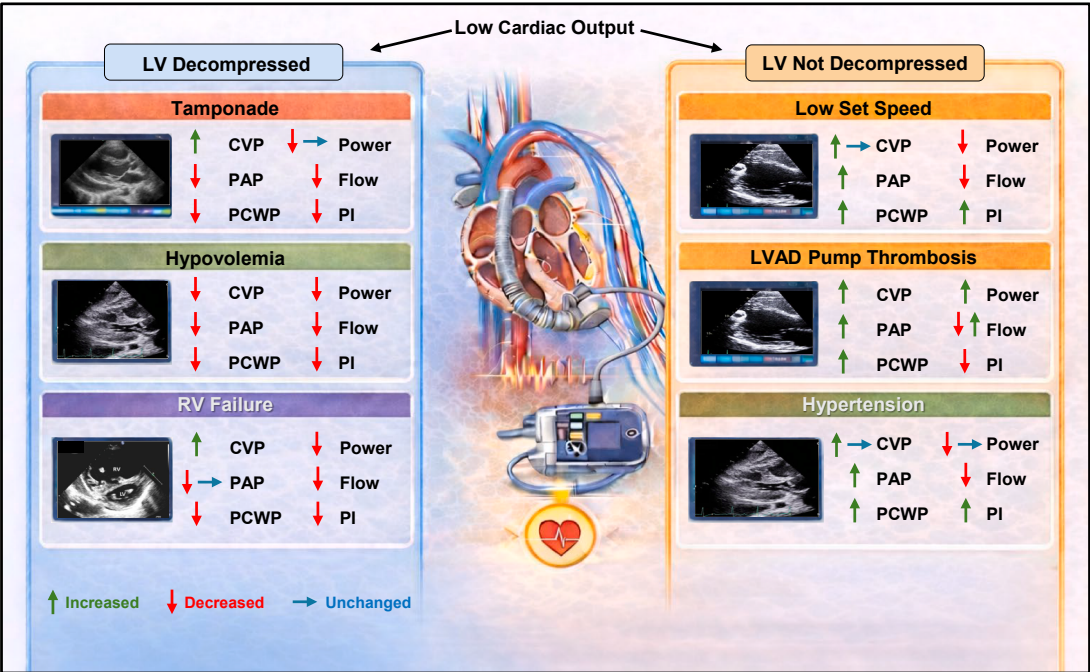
Multimodality assessment of low cardiac output after LVAD implantation. Integrated echocardiographic, invasive hemodynamic, and LVAD console data used to differentiate common causes of low cardiac output in continuous-flow LVAD patients. LV cavity size (decompressed vs not decompressed) is determined by echocardiography; CVP, PAP, and PCWP are obtained from invasive hemodynamic monitoring; and LVAD power, flow, and PI are derived from the LVAD console. Etiologies are stratified as LV decompressed (tamponade, hypovolemia, RV failure) or LV not decompressed (low pump speed, pump thrombosis, hypertension). Arrows denote direction of change relative to baseline (green = increased, red = decreased, blue = unchanged). CVP, central venous pressure; LVAD, left ventricular assist device; PAP, pulmonary artery pressure; PCWP, pulmonary capillary wedge pressure; PI, pulsatility index; RV, right ventricular.
